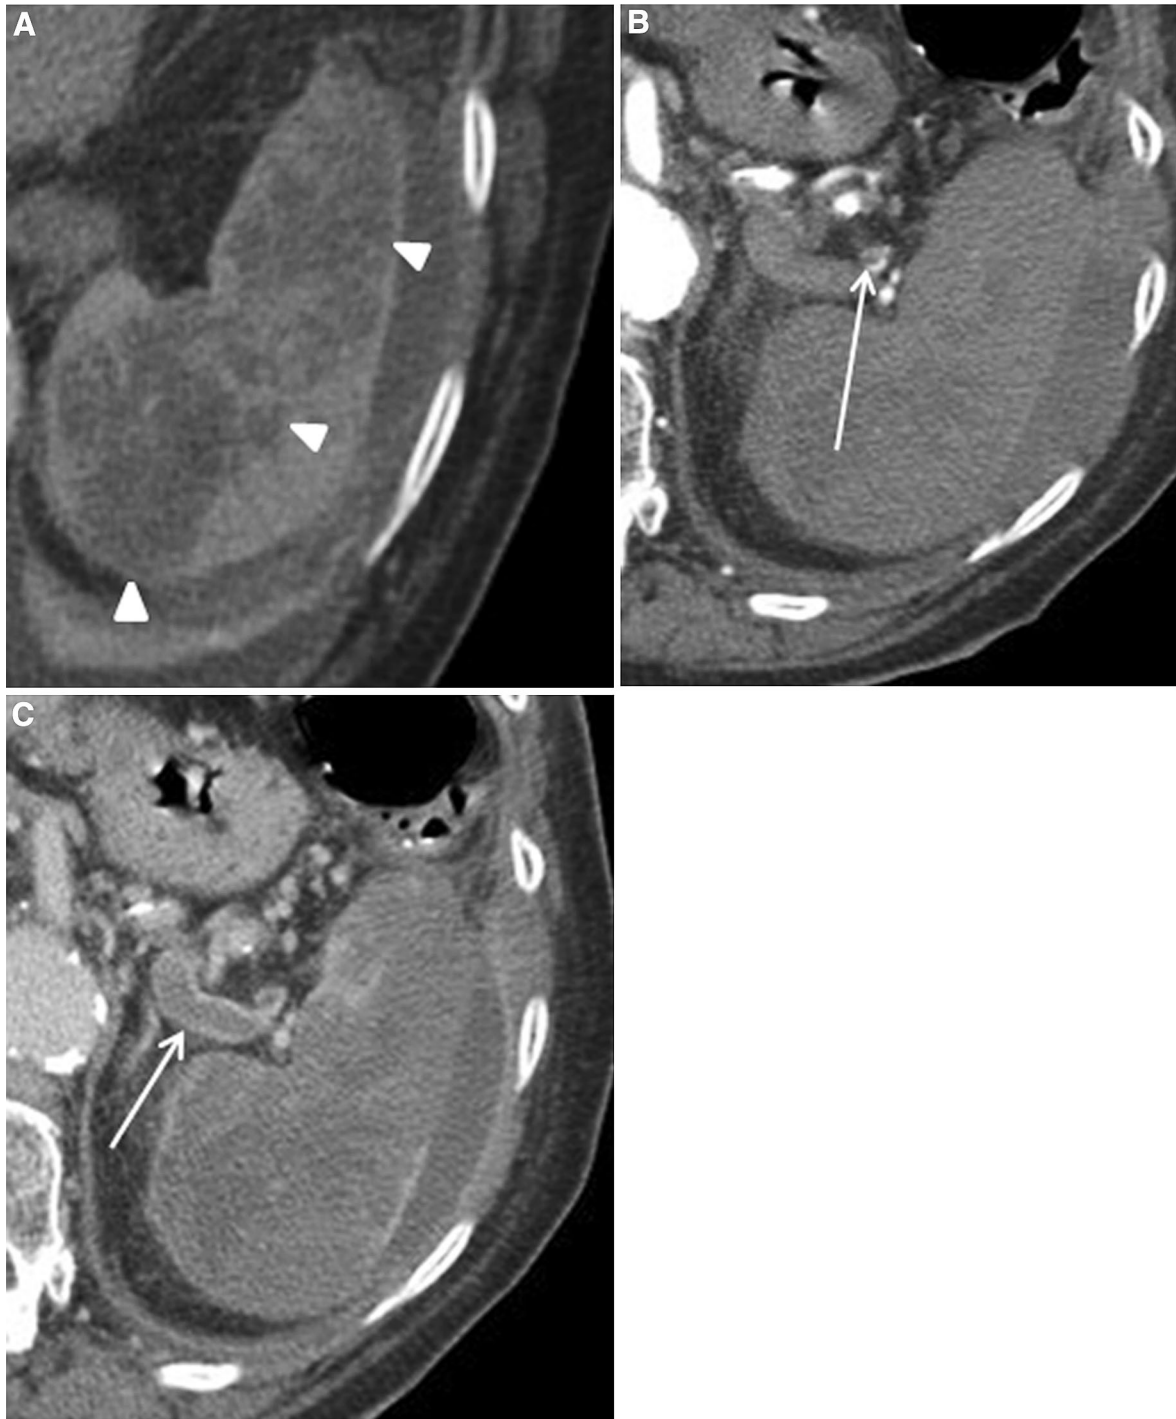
Splenic infarct. 58-year-old hospitalized man with abdominal pain. A Axial unenhanced CT shows low-attenuation areas in the splenic parenchyma (*arrowheads*). B Arterial and C portal venous phase contrast-enhanced axial CT
